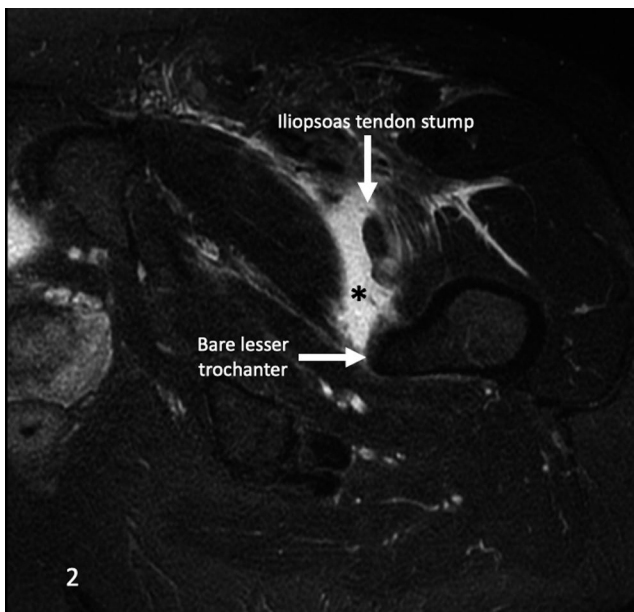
Left hip oblique-axial T2 MR image with fat saturation at the bare lesser trochanter with surrounding edema (*). A portion of the iliopsoas tendon stump is visible in this image
